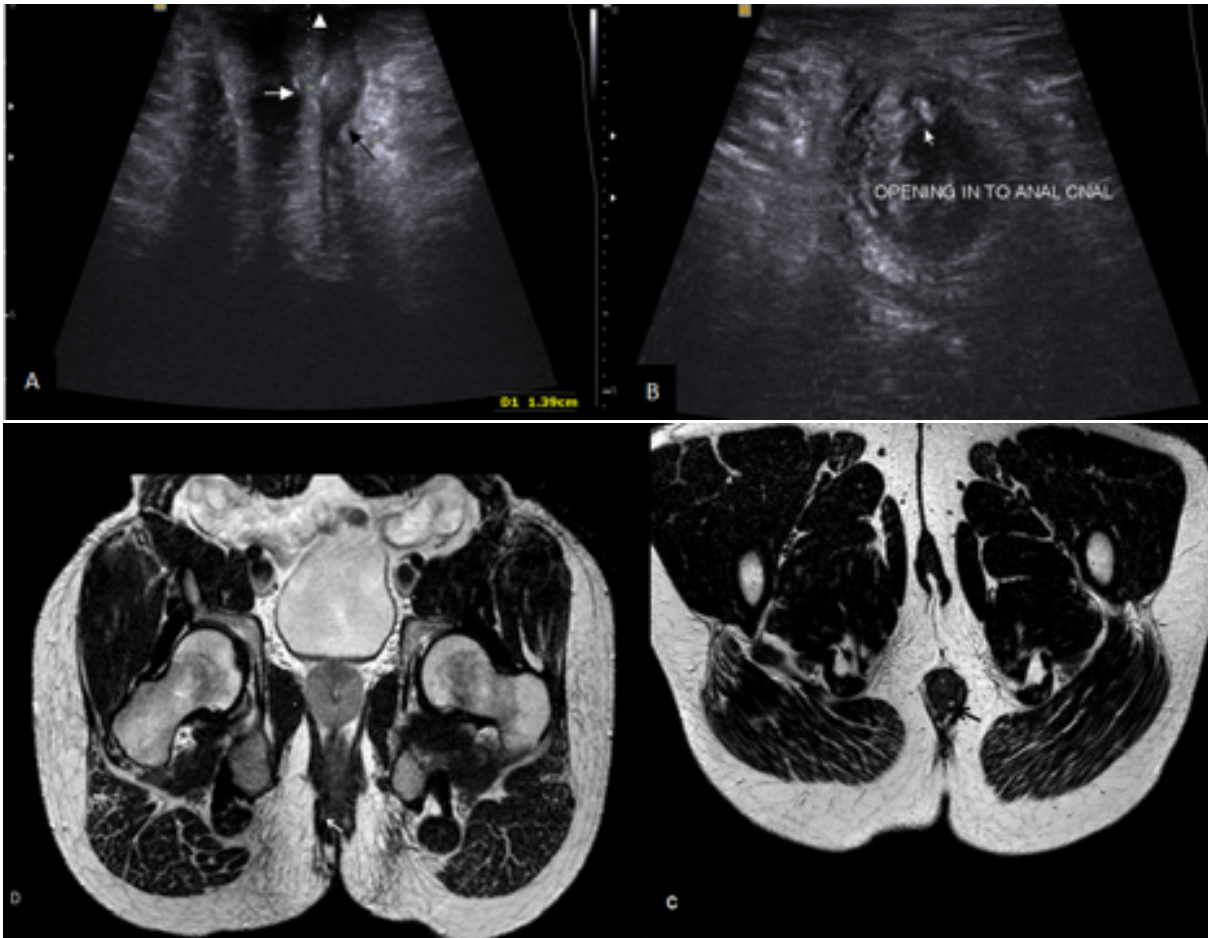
Intersphincteric fistula in ano. 1- TPUS; A- sagittal section ; showing tract with internal opening (white arrow) and its distance from anal verge (arrow head), Note branching of the tract in the intersphincteric plane below the line of internal opening, suggesting ramification (black arrow). B. axial section showing cross section of anal canal with fistula tract in the intersphincteric plane and its opening in to anal canal (white arrow). 2-T2WI MRI in axial (C) and coronal (D) planes, showing intersphincteric fistula in ano (arrows).
